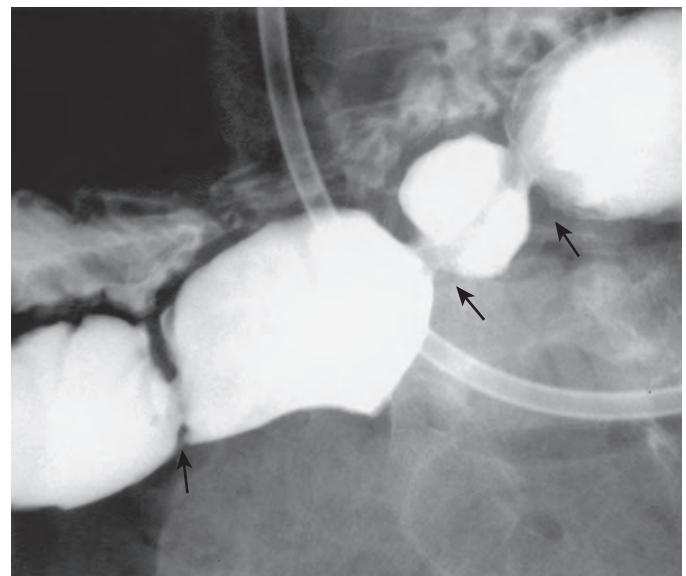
Strictures in ulcerative jejunoileitis complicating celiac disease. This spot radiograph from enteroclysis shows three short segments of ringlike narrowing (arrows) in the jejunum. (From Rubesin SE, Herlinger H, Saul SH, et al: *Adult celiac disease and its complications*. RadioGraphics 9:1045–1066, 1989.)
